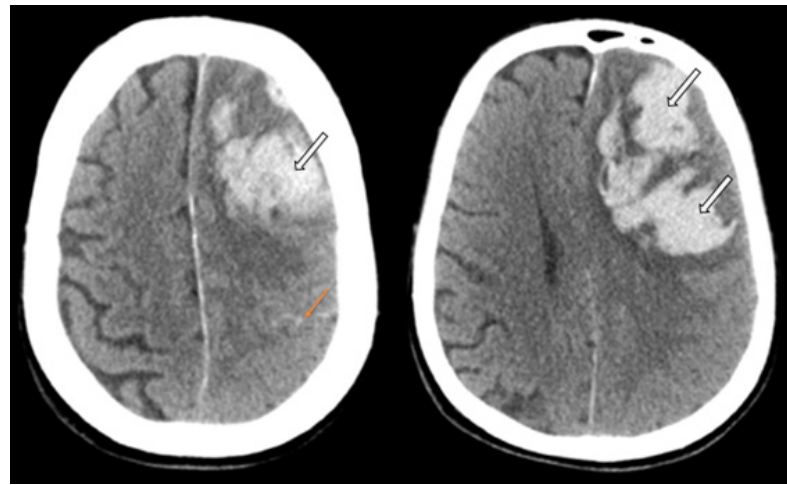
Unenhanced brain CT scan shows left frontal lobe hematoma and subarachnoid hemorrhage.
